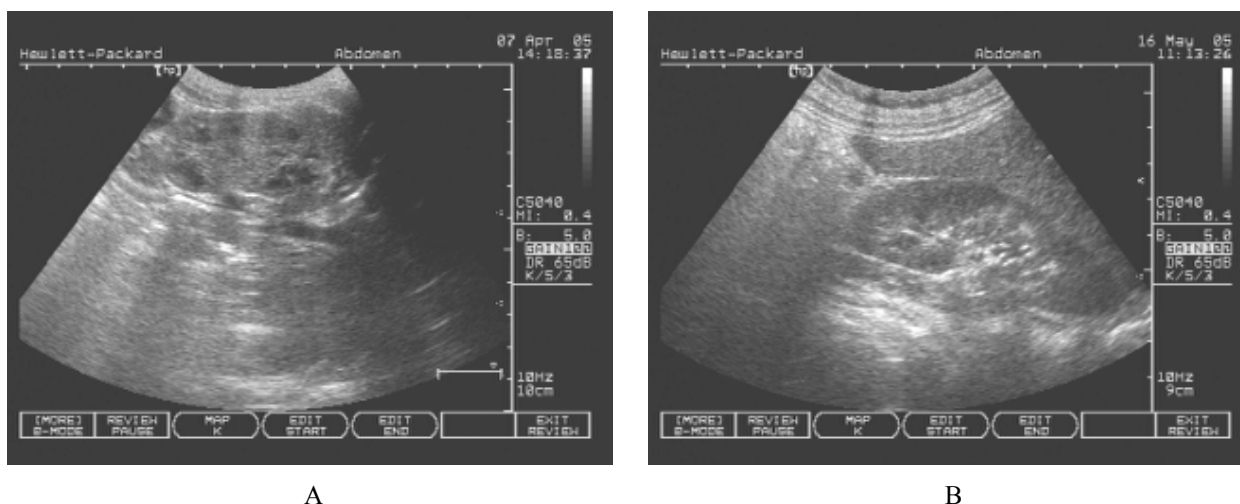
Echosonography of the kidney: A – newborn infant, 8th day; B – suckling infant, 10th month (with kindness of Predrag Miljković, MD, Children's Clinic, Clinical Center, Niš)
